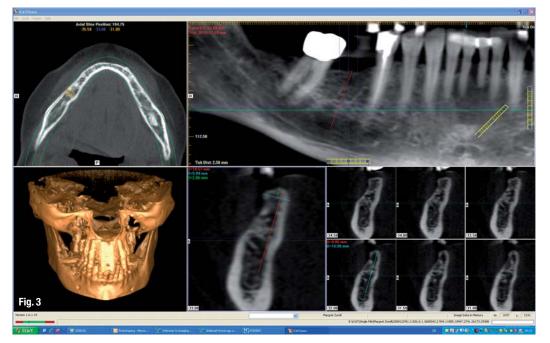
3_The CBCT images show the sloped atrophied alveolar ridge in region 46.
